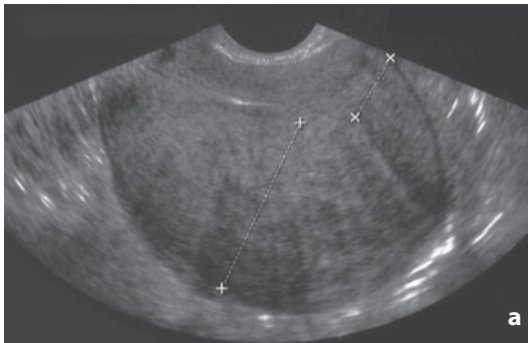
Ultrasonography. Adenomyosis, diffuse form. a A “comb-like” image can be visualized at the level of the posterior wall. Of special note is the asymmetrical thickness between the anterior and posterior walls (*crosses*). b Diffuse form. Hyperchoic foci (*arrows*) can be seen within the myometrium, and poor delineation of the junctional zone. c Diffuse form. Small cystic areas are visible within the myometrium
